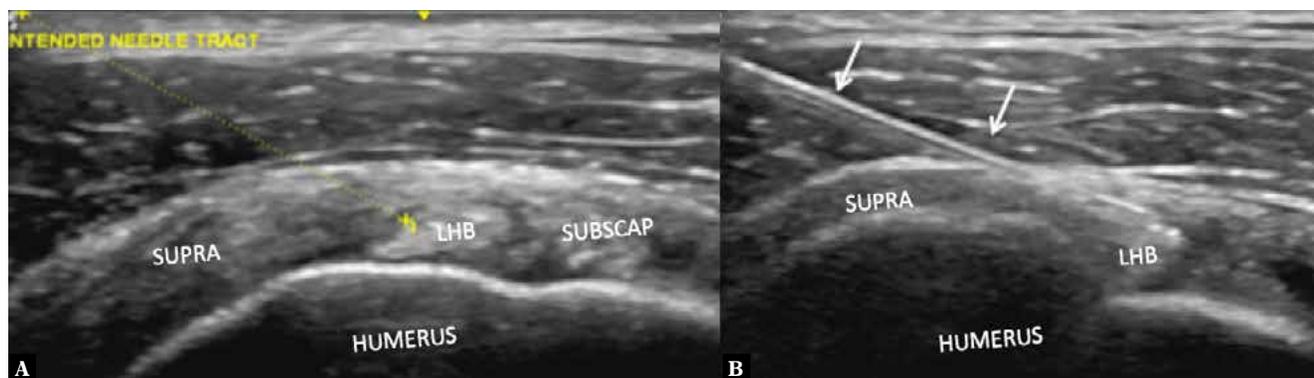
Axial ultrasound showing the indented trajectory of the needle (A) with a needle tip in the target zone (B) via lateral to medial approach
